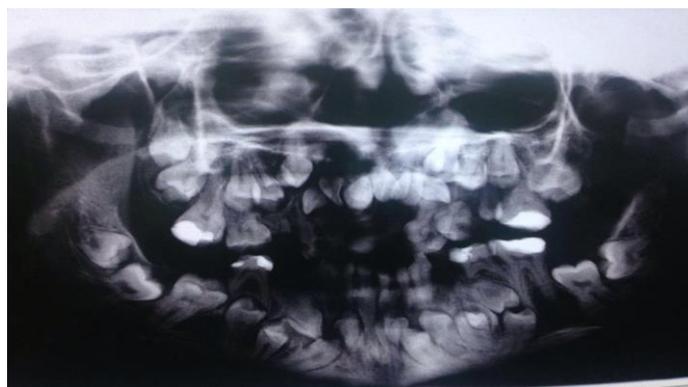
Panoramic radiography of the patient.
